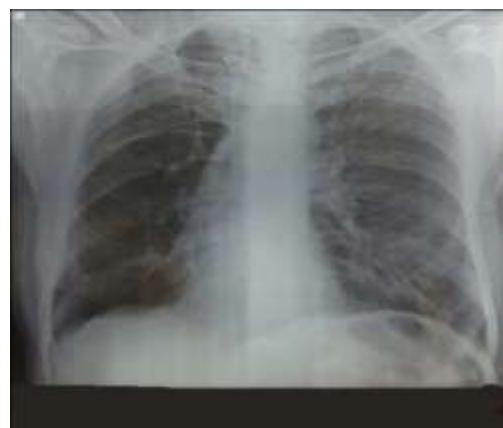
X-ray Chest (follow up) showed that there was ipsilateral shift of the mediastinum to the right side hyperlucent chest
